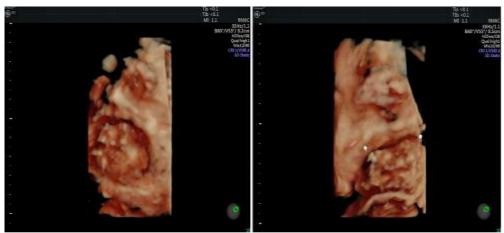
3D Static Ultrasound examination at 29 weeks of gestation showing the delineation of the cervical tumor.
